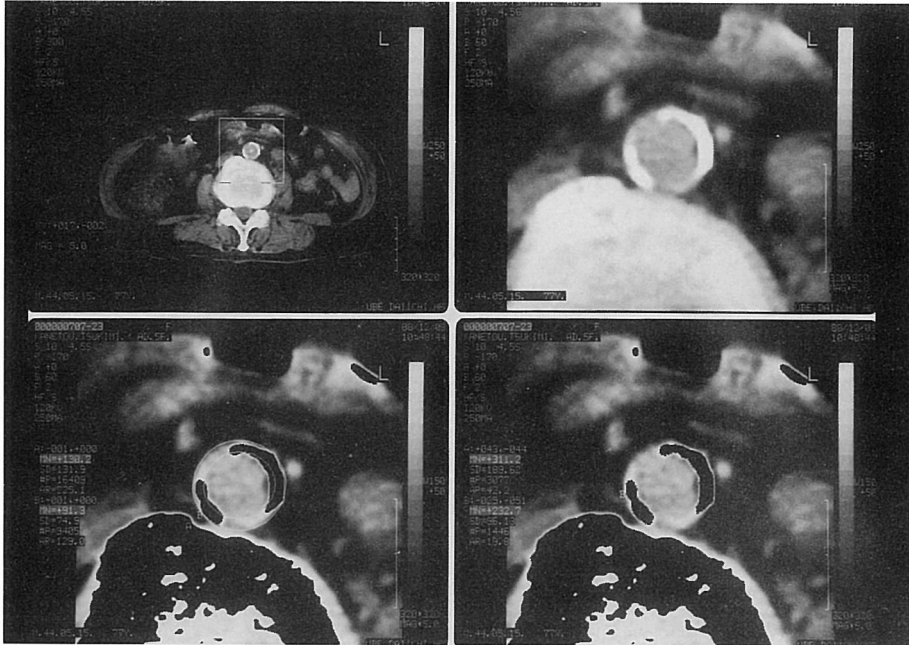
The measurement method of abdominal aortic calcification by computed tomography (CT).
